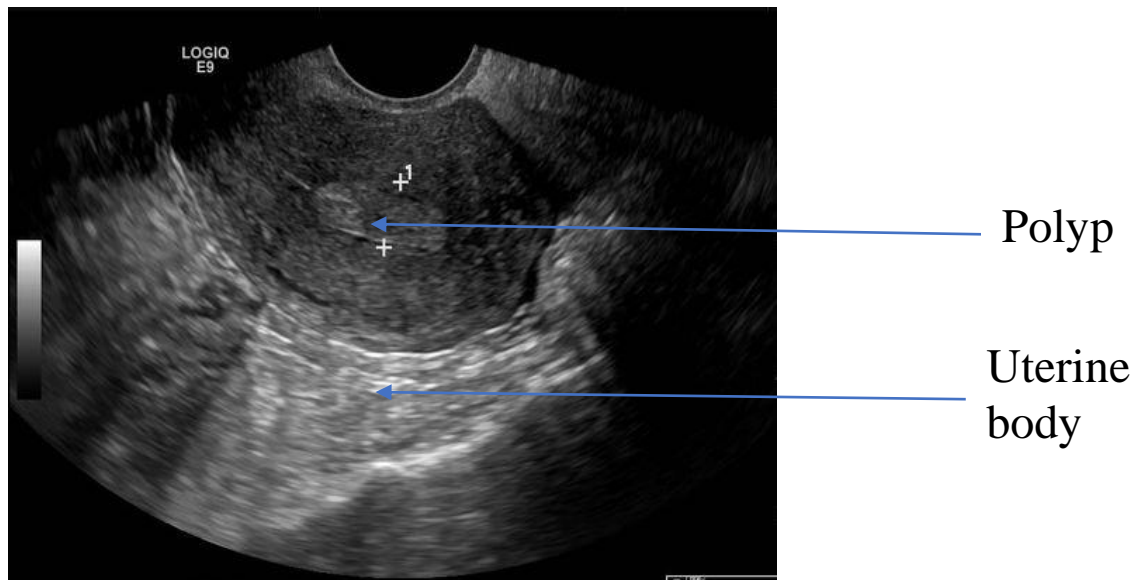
Transvaginal ultrasonography showing an endometrial polyp
